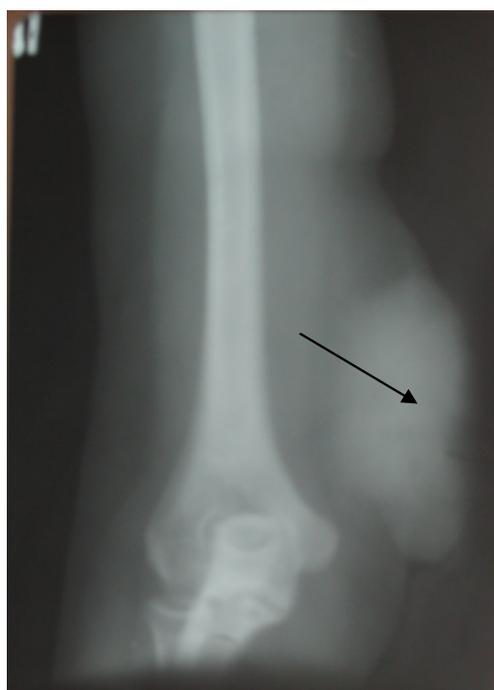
Enlargement X-ray film of the shoulder in a direct projection. pathological mass corresponding to soft tissues on density is situated in soft tissues in the bottom third of the shoulder. It has a form of an irregular oval with sharp contours (arrow). A tumour of shoulder soft tissues.
